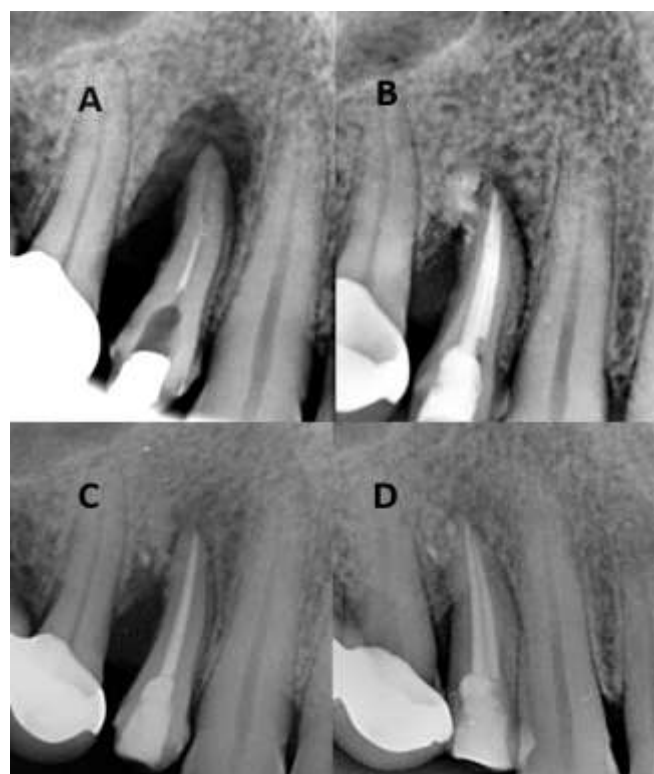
A) Preoperative radiograph; B) Postoperative radiograph at 6 months; C) Postoperative radiograph at 9 months; D) Postoperative radiograph at 1 year
